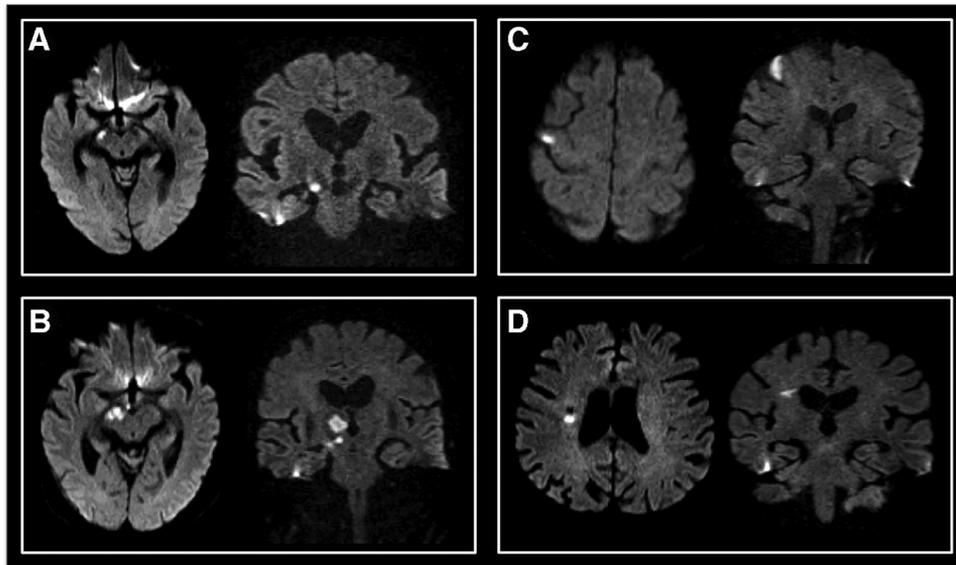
Transversal/coronal diffusion-weighted magnetic resonance imaging in four patients (A/B/C/D) with isolated central facial palsy. Patient (B) has an additional lesion of the right inferomedial thalamus.
